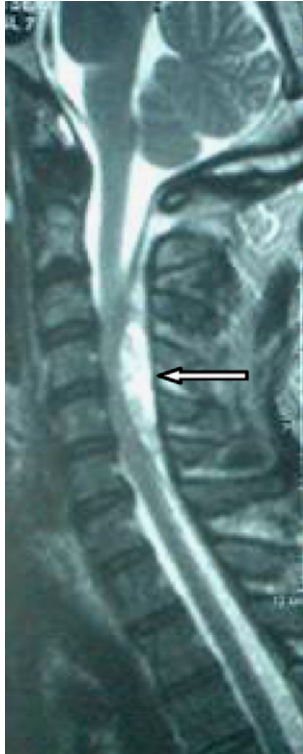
Sagittal T2-weighted images showing an epidural haematoma between C3 and C6.
